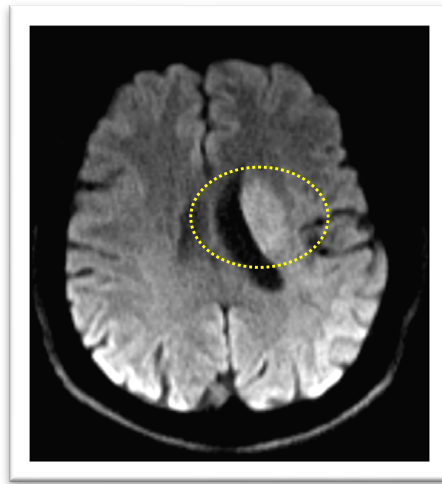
Brain diffusion MRI of Case 5 showing infarct in the left lentiform nucleus, head and body of caudate nucleus (as highlighted by yellow dotted circle).
